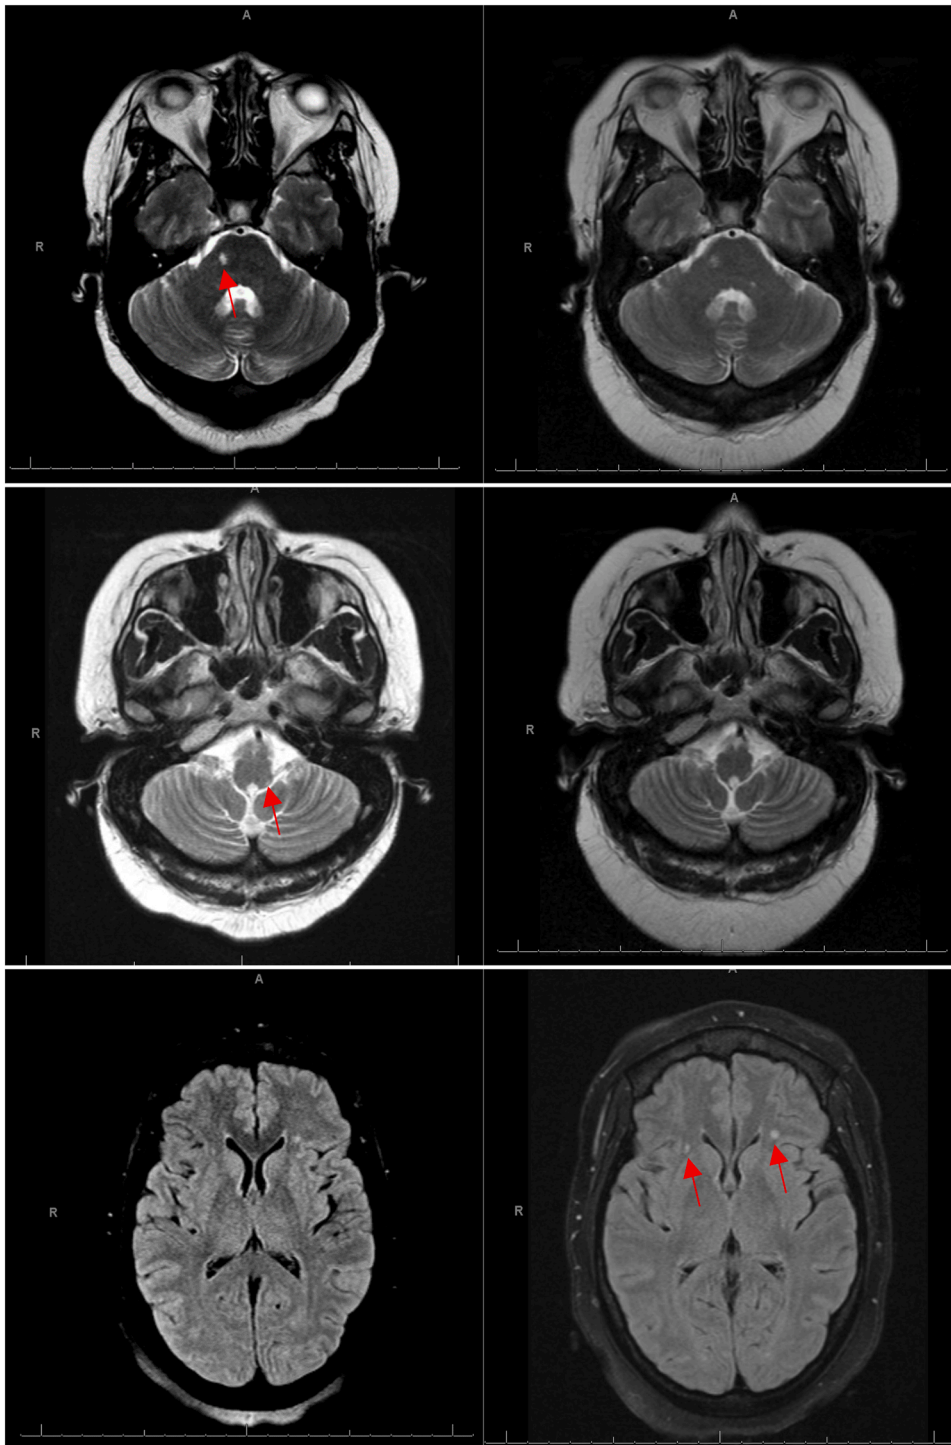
MRI brain on initial presentation with lateral medullary syndrome. *Top Row; Left to Right:* DWI, ADC, and T2 demonstrating acute infarction of the left postero-lateral medulla. *Middle Row; Left to Right:* DWI, ADC, and T2 demonstrating chronic infarction of right lateral pontine. *Bottom Row:* Hyper-intense and non-specific foci in the right parietal and left frontal lobes on T2 FLAIR suggestive of subacute infarctions.
